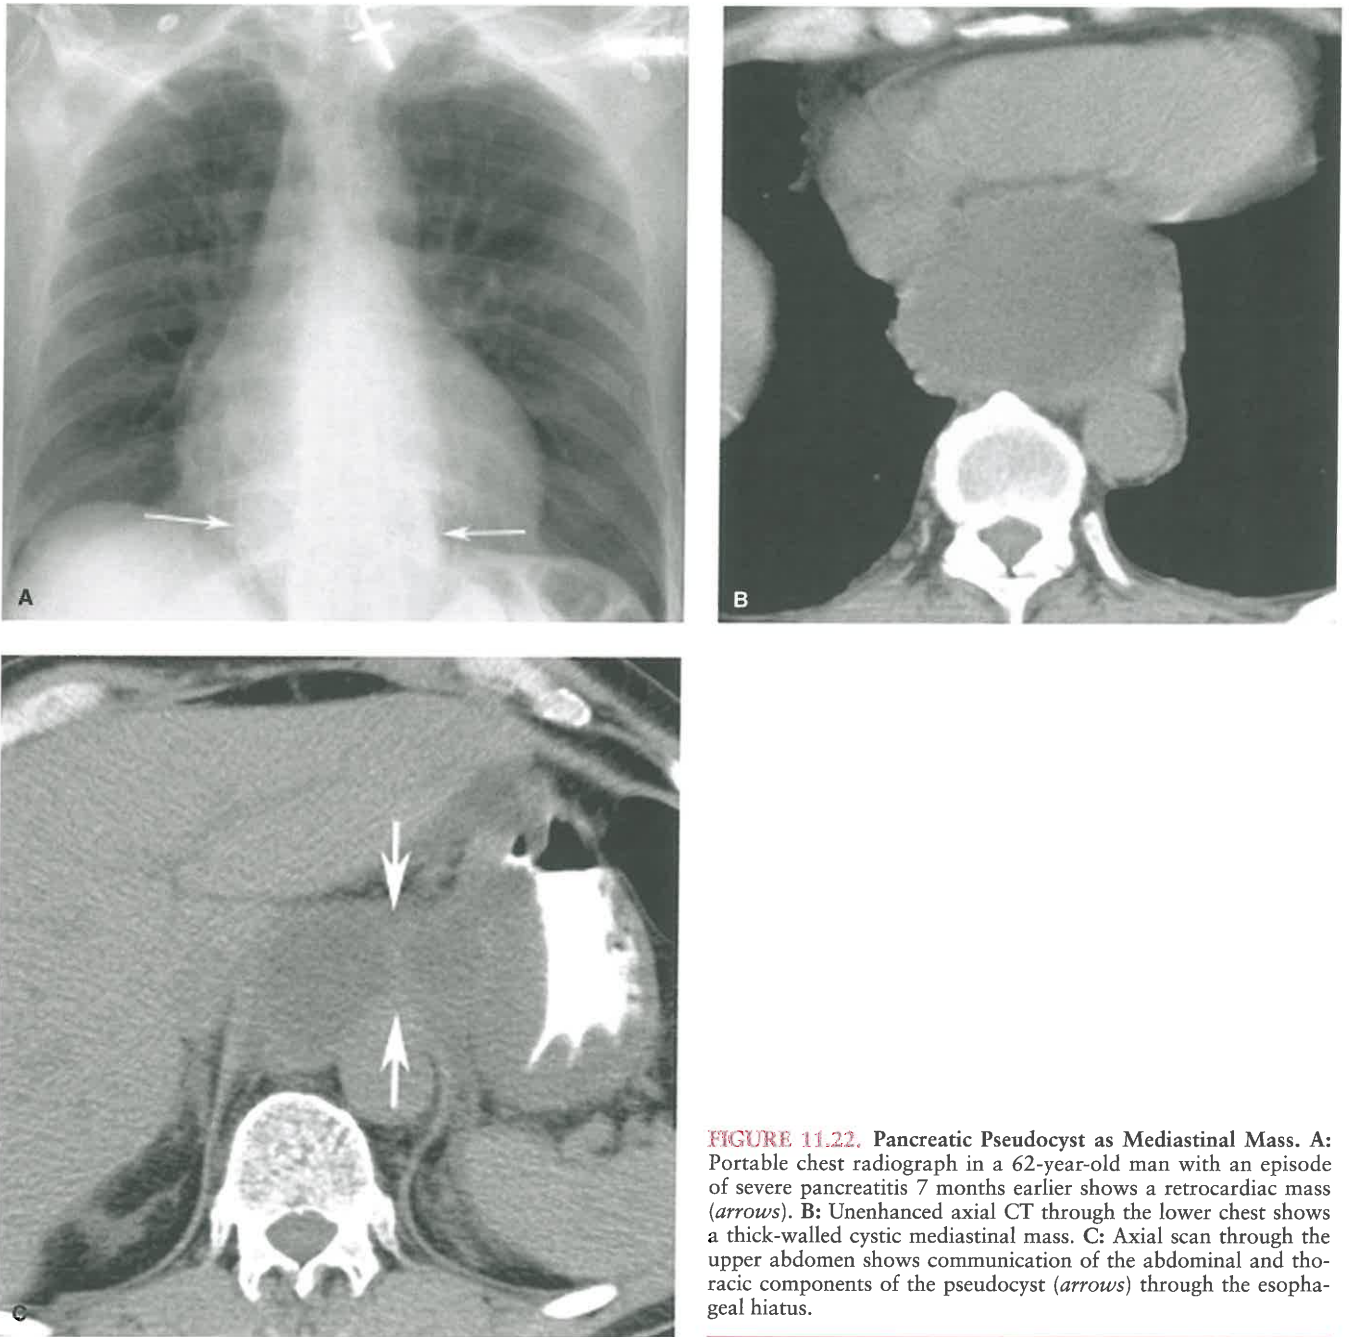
Pancreatic Pseudocyst as Mediastinal Mass. A: Portable chest radiograph in a 62-year-old man with an episode of severe pancreatitis 7 months earlier shows a retrocardiac mass (arrows). B: Unenhanced axial CT through the lower chest shows a thick-walled cystic mediastinal mass. C: Axial scan through the upper abdomen shows communication of the abdominal and thoracic components of the pseudocyst (arrows) through the esophageal hiatus.
